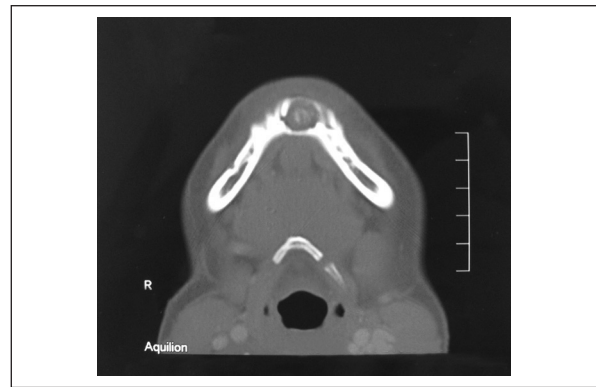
CT scan presents the calcifications.
